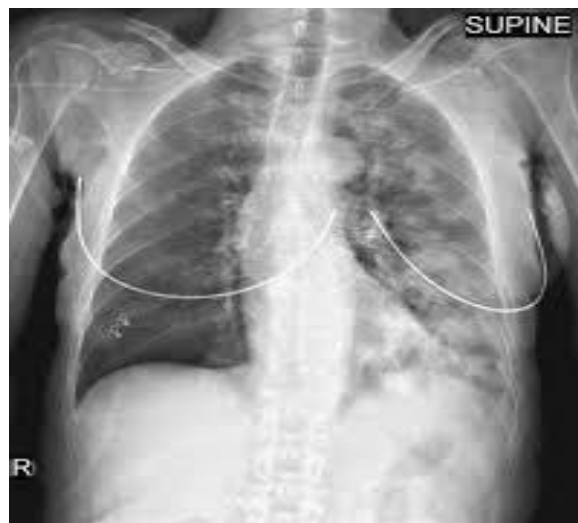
Chest X-ray findings of Aspiration pneumonitis
